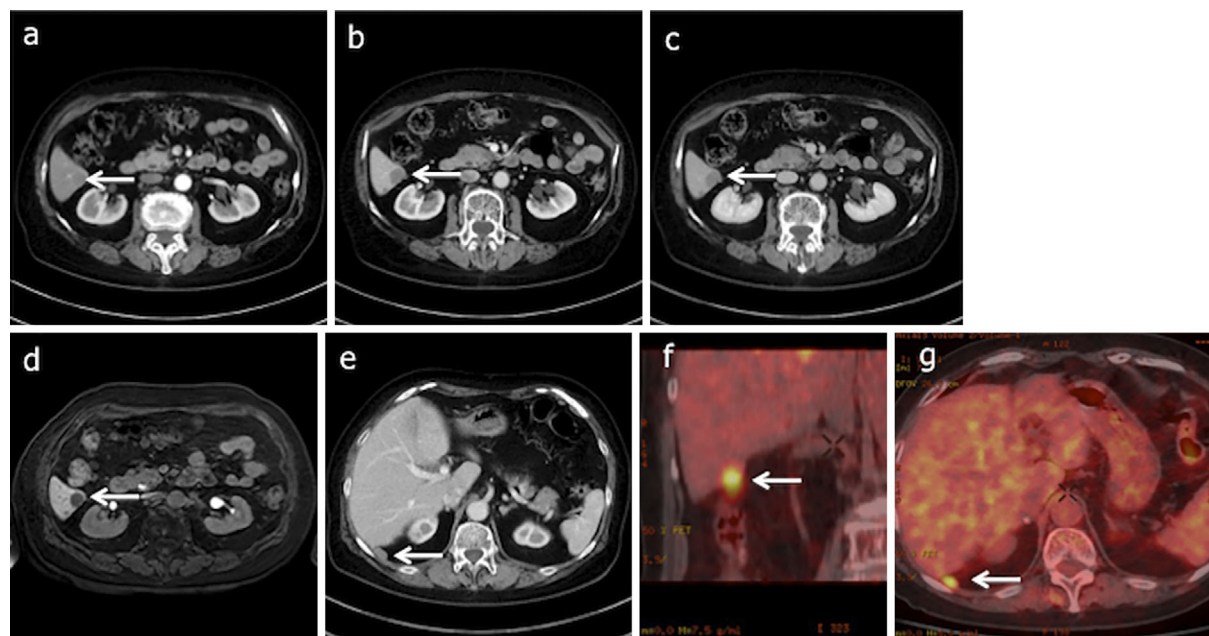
(a-c) Liver dynamic CT. (a) Arterial phase, (b) portal phase, and (c) delayed phase. Dynamic CT of the liver showed a low-density mass with internal enhancement in the S6 area in the arterial and delayed phase (arrows). (d) The hepatobiliary phase of Gd-EOB-DTPA-MRI shows a single nodule in the liver S6 (arrow). (e) Contrast CT showed a low-density mass located at the right retroperitoneal cavity (f, g) PET-CT. The SUV_{max} of the tumor in S6 of the liver was 7.3 (f, arrow), and that of the retroperitoneal tumor was 3.8 (g, arrow).
